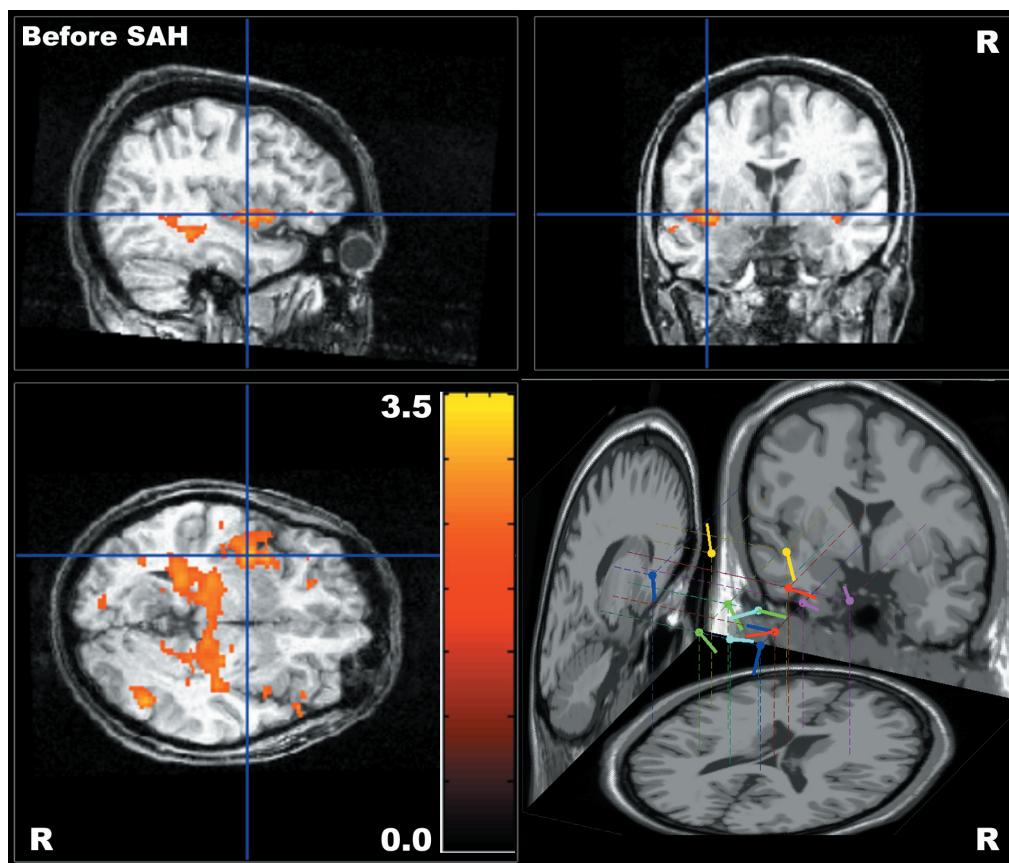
Blood oxygen level-dependent (BOLD) contrast activation responses associated with all interictal epileptiform discharges recorded before selective amygdalohippocampectomy (SAH) and coregistered to the patient's brain structural magnetic resonance imaging. The color bar indicates T-values for positive BOLD responses. In the right lower view of this figure, dipoles to independent component analysis (ICA) are shown in the Montreal Neurological Institute standard brain, with left-sided predominance. Each dipole color indicates an individual ICA component.
